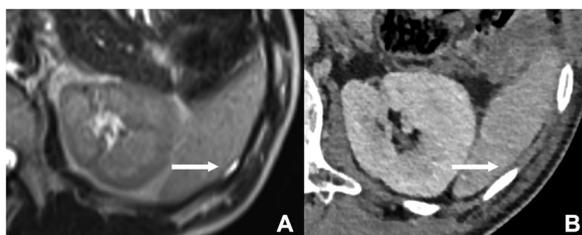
46-year-old man with peritoneal carcinomatosis from mucinous tumor of the appendix and splenic involvement. T2-weighted MR image in the transverse plane reveals perisplenic mucinous implant (arrow) (A). No lesion is visible on CT image in the same area (arrow) (B).
